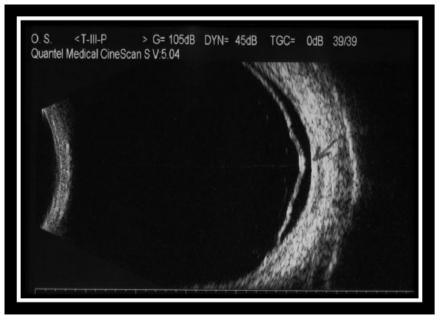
B-scan ocular ultrasound of retinal detachment (Courtesy of Mitzy Torres Soriano MD).
